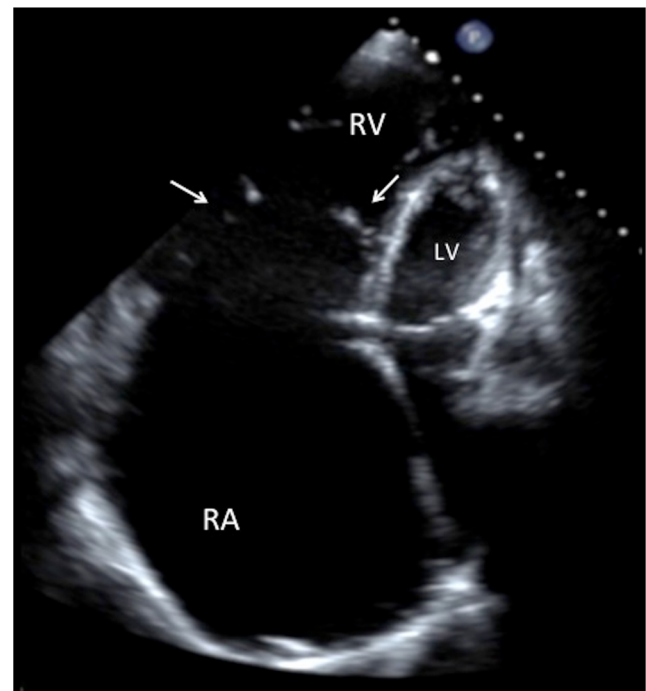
Apical four-chamber view in a patient with Ebstein's anomaly of the tricuspid valve. The image shows the tethering and apical displacement of the tricuspid valve leaflets (arrows) with dilated right atrium and atrialized RV (LV left ventricle, RA right atrium and atrialized RV, RV right ventricle)
